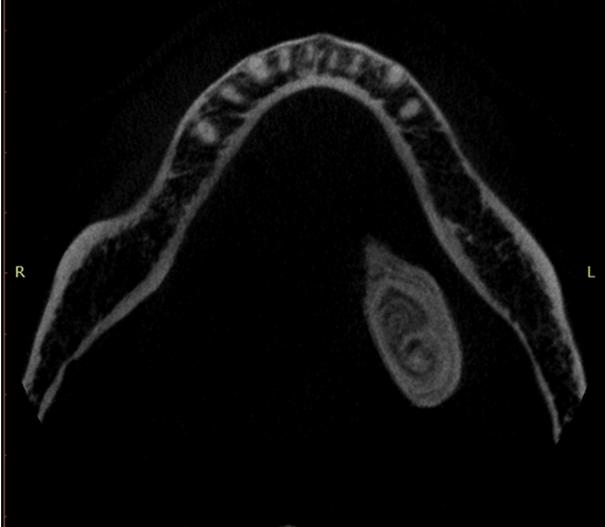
Patient 1. Cone-beam computed tomography image, transverse sectional view, of a patient with a megalith located at the level of the left submandibular gland infundibulum. In this patient, the size of the calculus rendered it easy to find intraoperatively; however, the shape and dimensions are also important to allow for the reconstitution of the stone in the case of fragmentation and to ensure complete removal.
